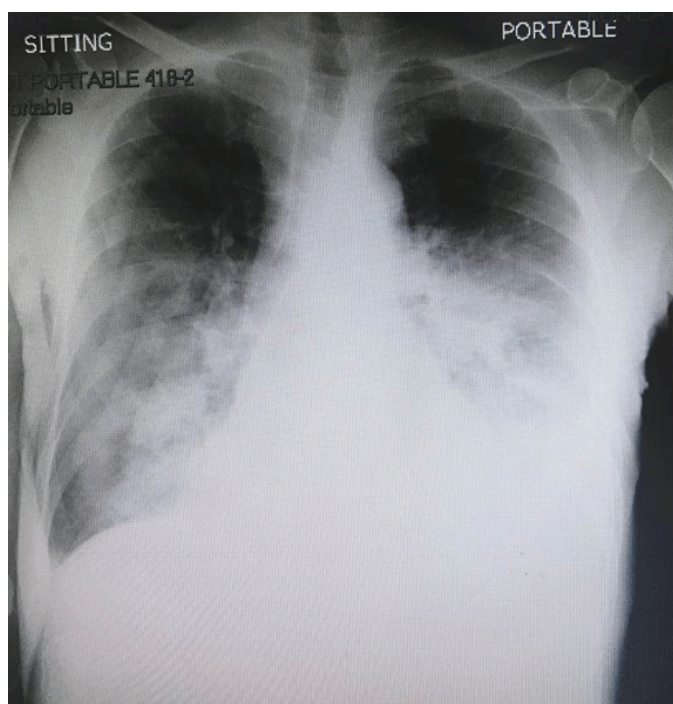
Chest X-ray showing worsening of bilateral airspace disease.
